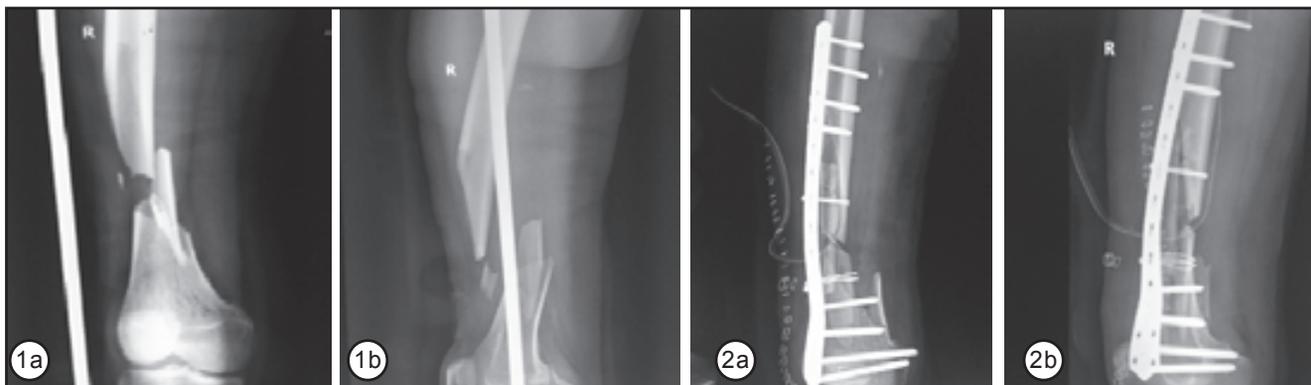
a & b: Pre-operative X-rays
